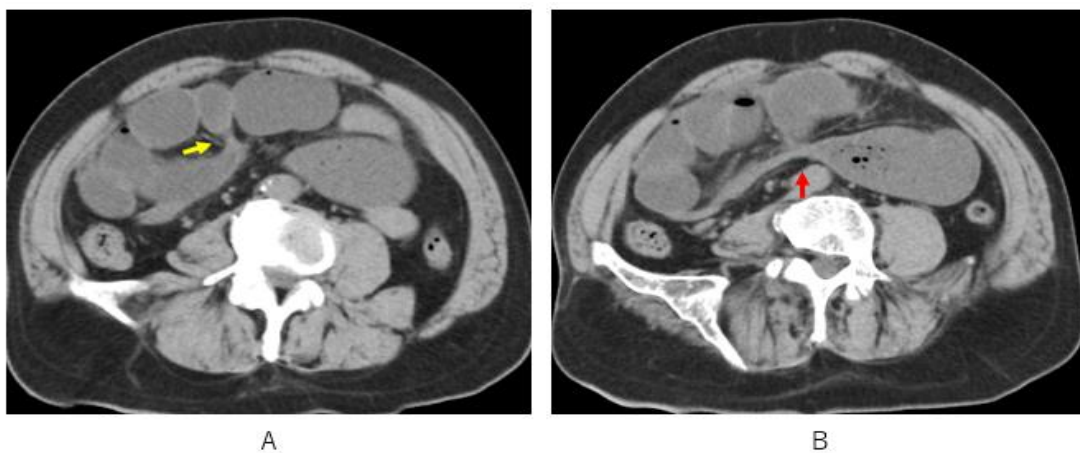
There are two beak sign or two knot sign on axial CT that indicates one is the transposition between oral dilated bowel and oral closed loop (A, yellow arrow), and another is the transposition between anal closed dilated loop and constrictive anal bowel (B, red arrow). However, these knots look somehow loose and not so tightening.
